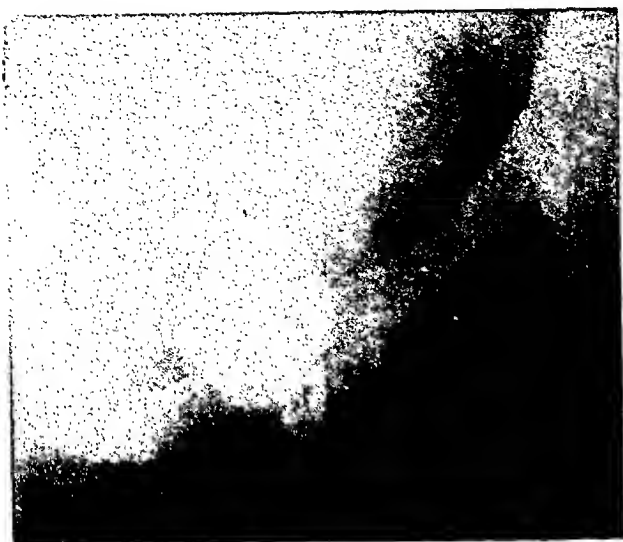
Case VI. Roentgenographic evidence of a chronic supralelevator cavity complicating an old ischio-rectal abscess. The cavity above the levator had not been detected at two previous operations to obliterate the ischio-rectal sinus.
